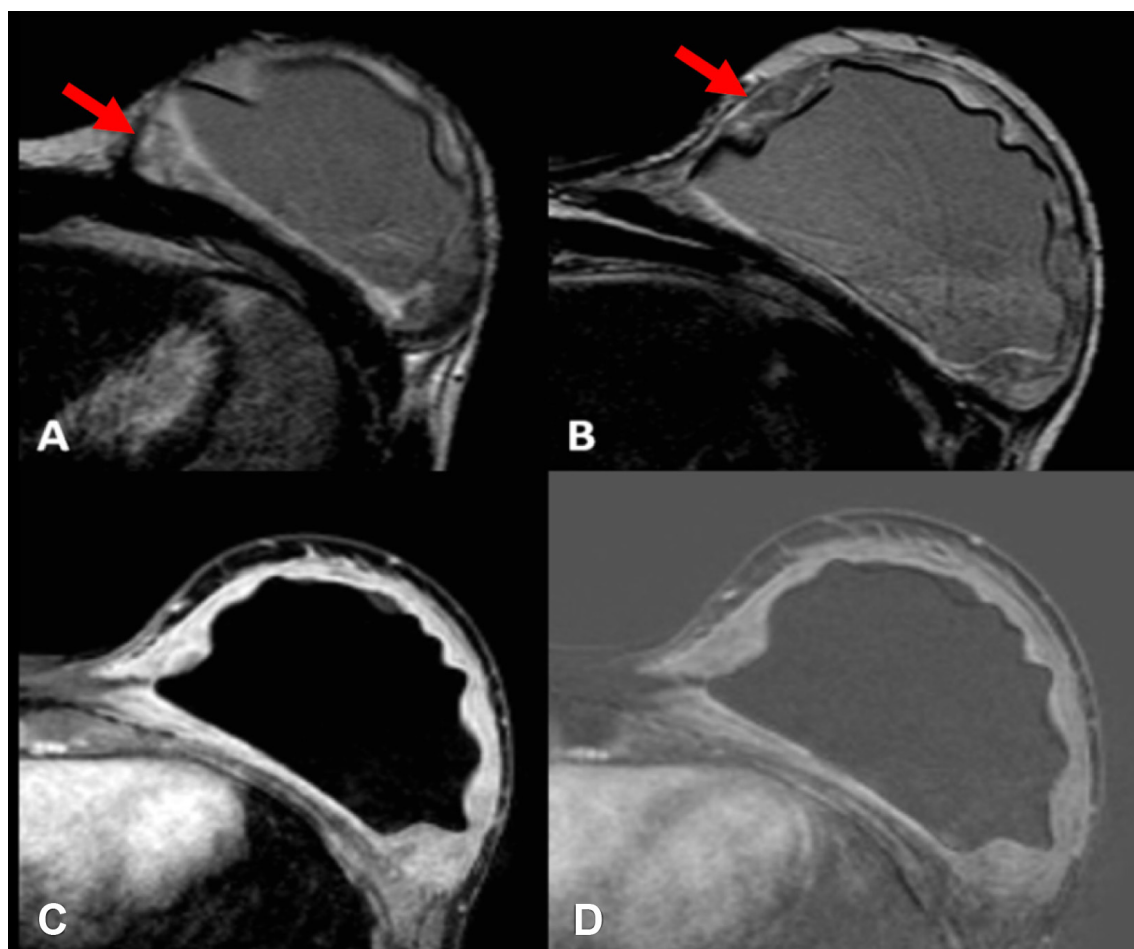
Case #2. MRI images: T2 sequences (A, B); T1 sequence after contrast material injection (C); subtracted T1 sequence after contrast material injection (D). Notice diffuse thickening of both the fibrous capsule and the hypointense amorphous material in all sequences along the outer margins of the left prosthesis caused by fibrin deposits (arrows).
